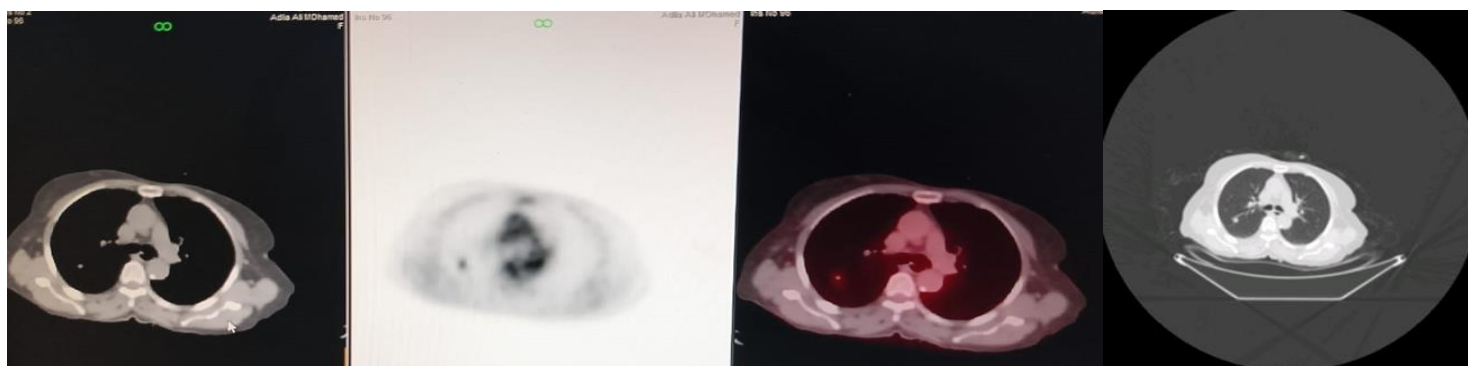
male patient, 62 years old with cancer colon, PET CT revealed pulmonary nodule of average 12mm with SUV max 4 with (lung window).
